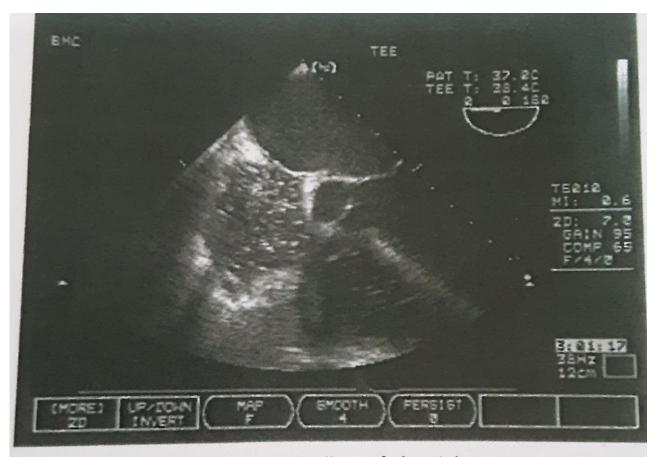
Venous air embolism of the right atrium visible with transesophageal echocardiographic monitoring.
